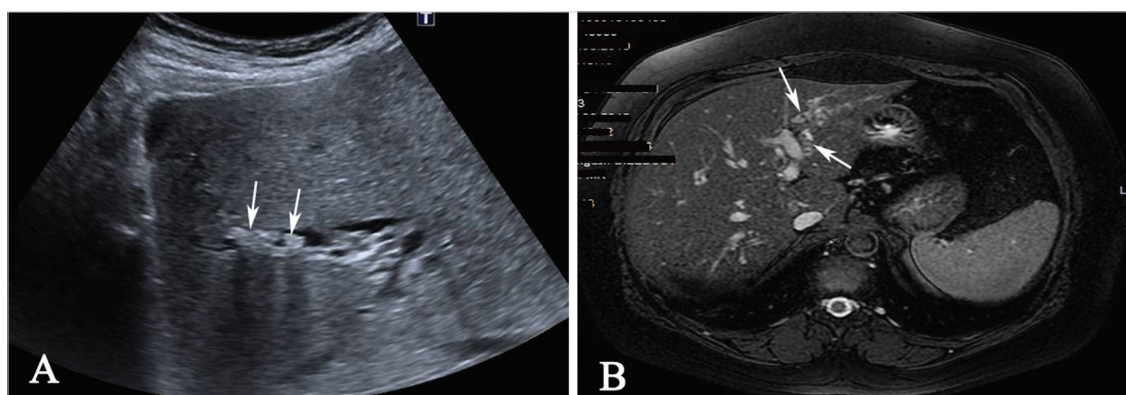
The ultrasonography of the liver shows (A) the stones in the left hepatic bile ducts and their reflections (acoustic shadow). Axial tomography section (B) of the same patient shows multiple stones in the left lateral sector.
